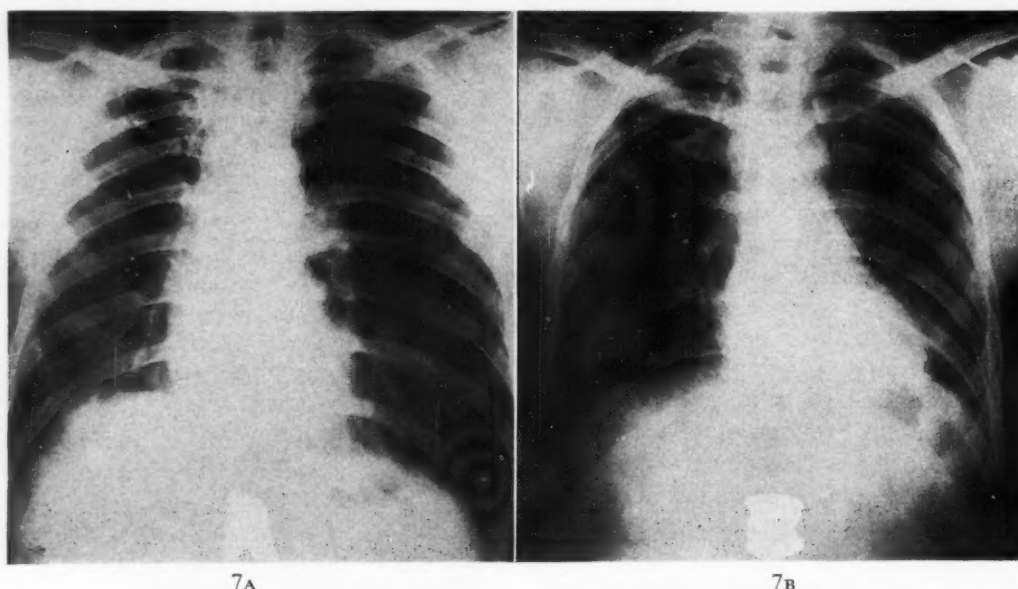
Case VII. Roentgenograms of chest; A, full inspiration; B, full expiration.
